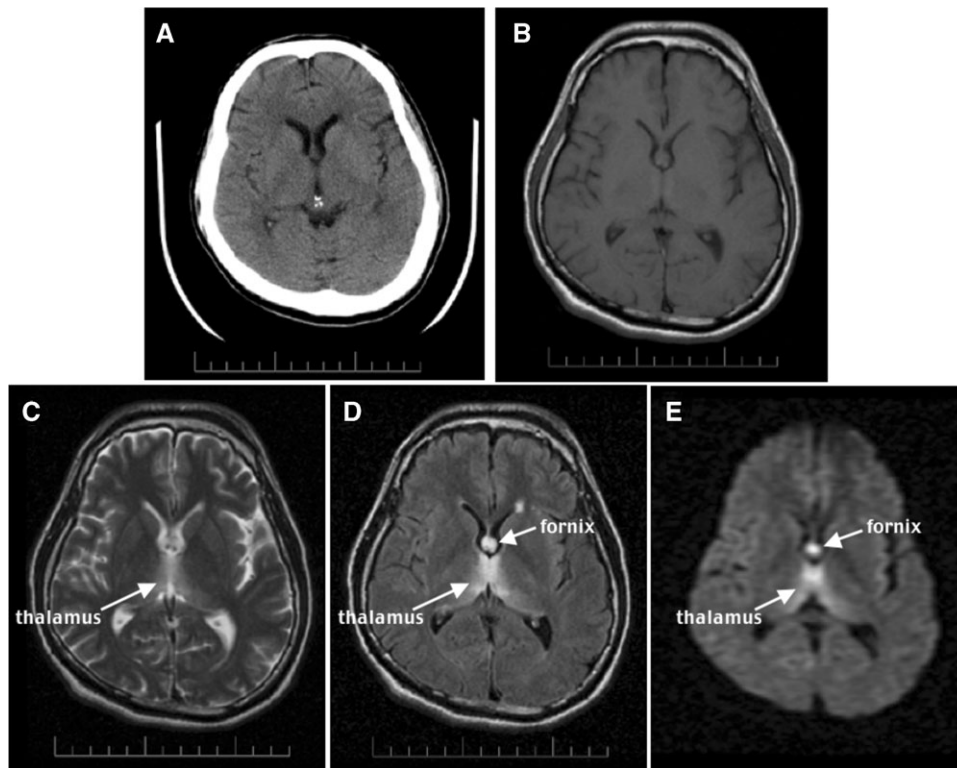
CT and MR images of an acute 35-year-old man with schizophrenia and acute nutritional deficiency-induced WE. (A) Axial CT at the level of the lateral ventricles. (B–E) Axial MR images at a similar level to the CT. (B) A proton density-weighted image. (C) A T2-weighted late-echo fast spin echo (FSE) image. (D) A fluid-attenuated inversion recovery (FLAIR) image. (E) A diffusion-weighted image (DWI). Note the hyperintensity of the fornix and thalamus, especially in D and E, less so in C, and lack of lesion conspicuity in A and B.
